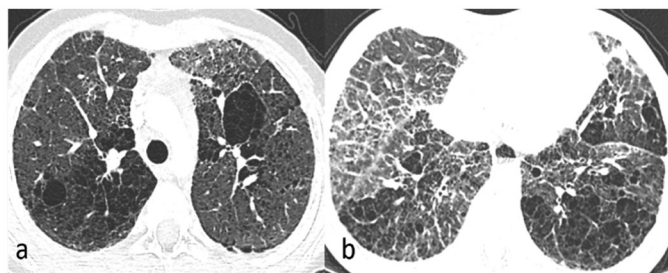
A 13-year-old boy with primary immunodeficiency (severe combined immunodeficiency). Chest computed tomography images (a, b) show linear and reticular opacities, ground-glass opacities, interlobular septal thickenings, emphysematous changes, and multiple cysts resulting in a honeycomb appearance in both lungs. Childhood interstitial lung disease findings are compatible with lung fibrosis.
